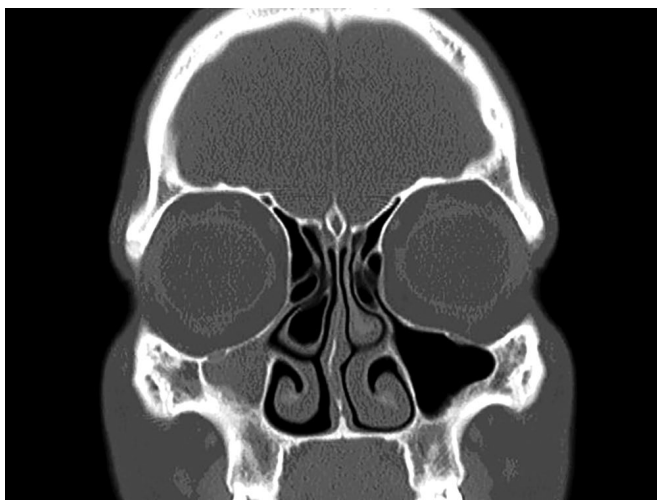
Coronal computed tomography scan of a patient with a concha bullosa of the right middle turbinate, hypoplasia of the right maxillary sinus and atelectasis of the uncinate process.
